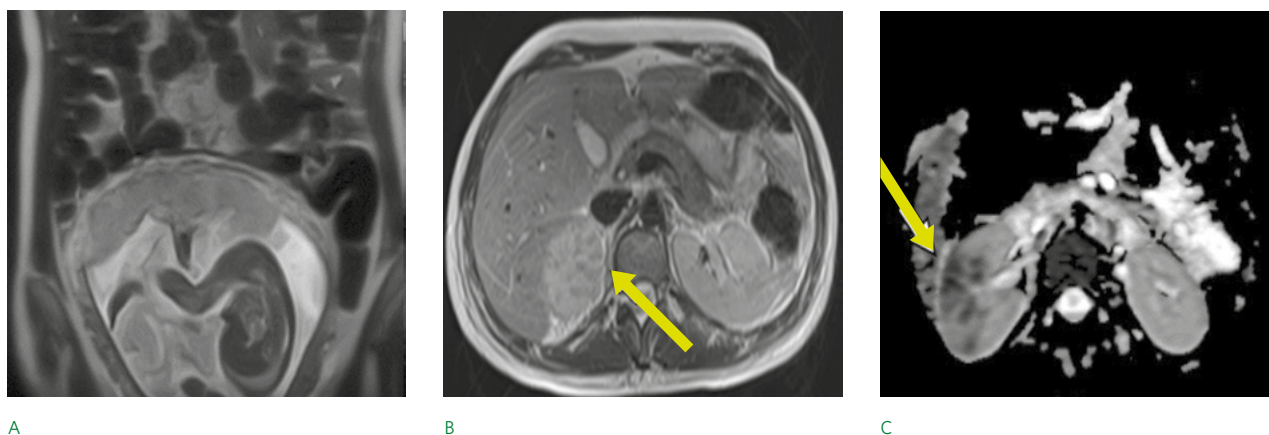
MRI of patient K., 32 years old (pregnancy 21-22 weeks):
